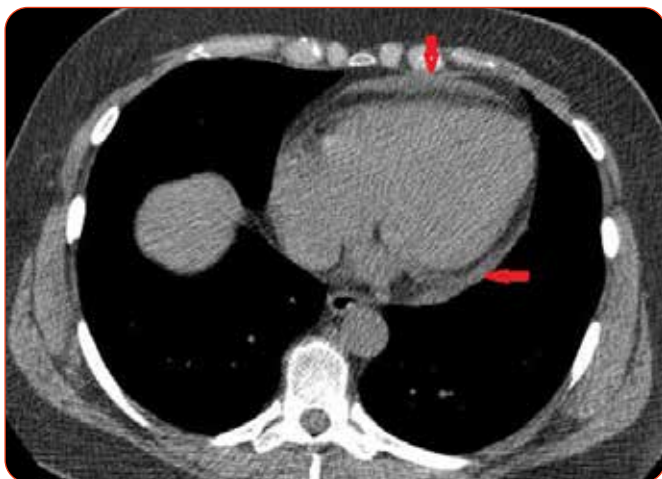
Axial CT scan showing a small pericardial effusion (red arrows).
